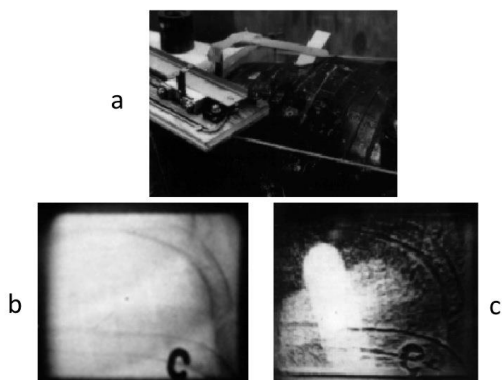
Enhancement of periodic x-ray contrast using dual storage tube apparatus. Figure 3a shows the apparatus. 3b shows the unsubtracted image. 3c shows the integrated subtraction result.
